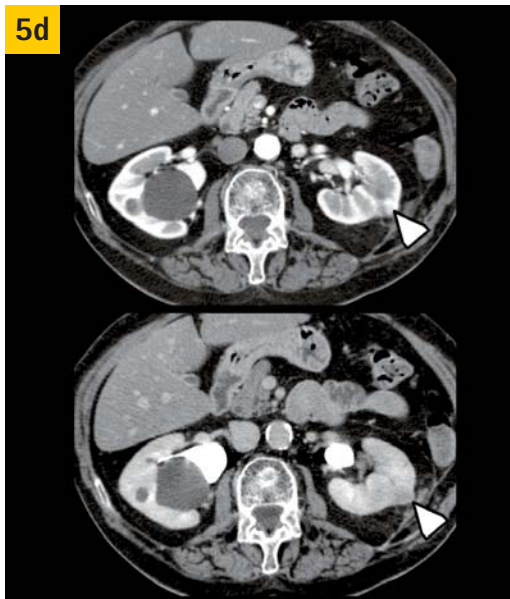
Contrast-enhanced CT performed at six weeks (immediately before the second RFA session) confirmed the diagnosis of 2 renal tumor residues at the upper anterior part of the ablated area (Fig. 5d) and lower posterior part of the ablated area (Fig. 5e).
